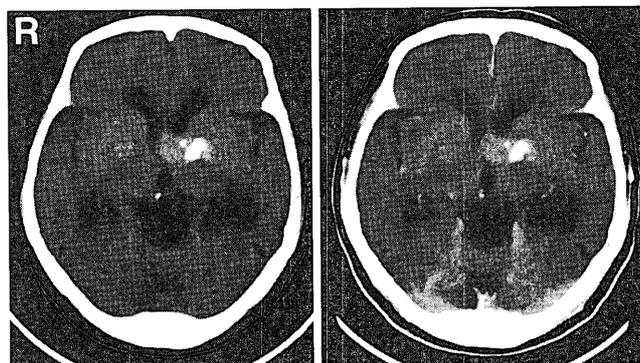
Computed tomography scans showing a partially calcified mass lesion (left) without enhancement (right) in the left caudate head and mild ventricular dilation.
